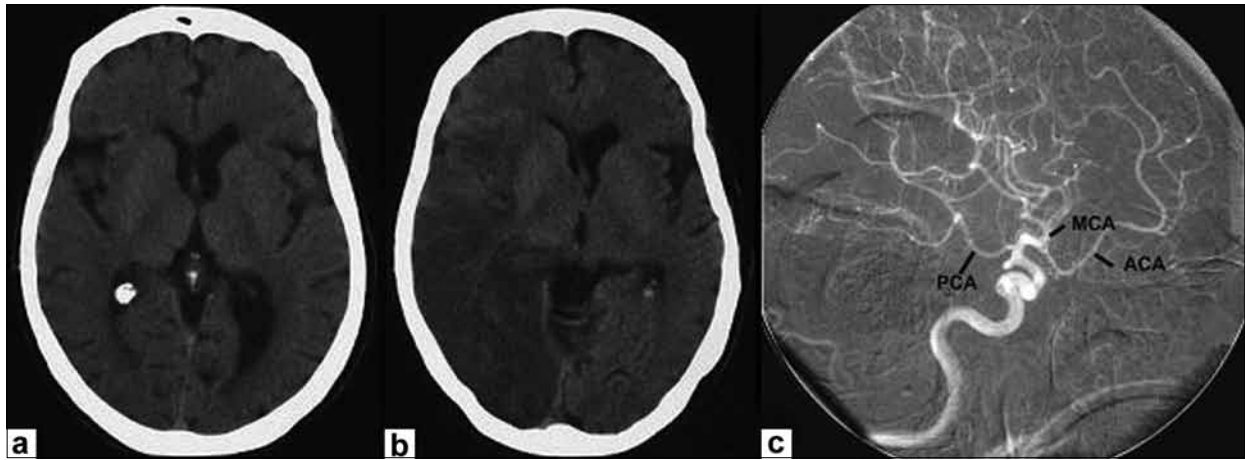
(a) Normal initial CT of the patient; (b) The cranial CT two days after the incident shows signal changes consistent with simultaneous infarcts in the right MCA and PCA areas; (c) In the digital subtraction angiography of the right ICA, PCA is seen to originate from the right ICA through PCoA i.e. fetal type PCA
